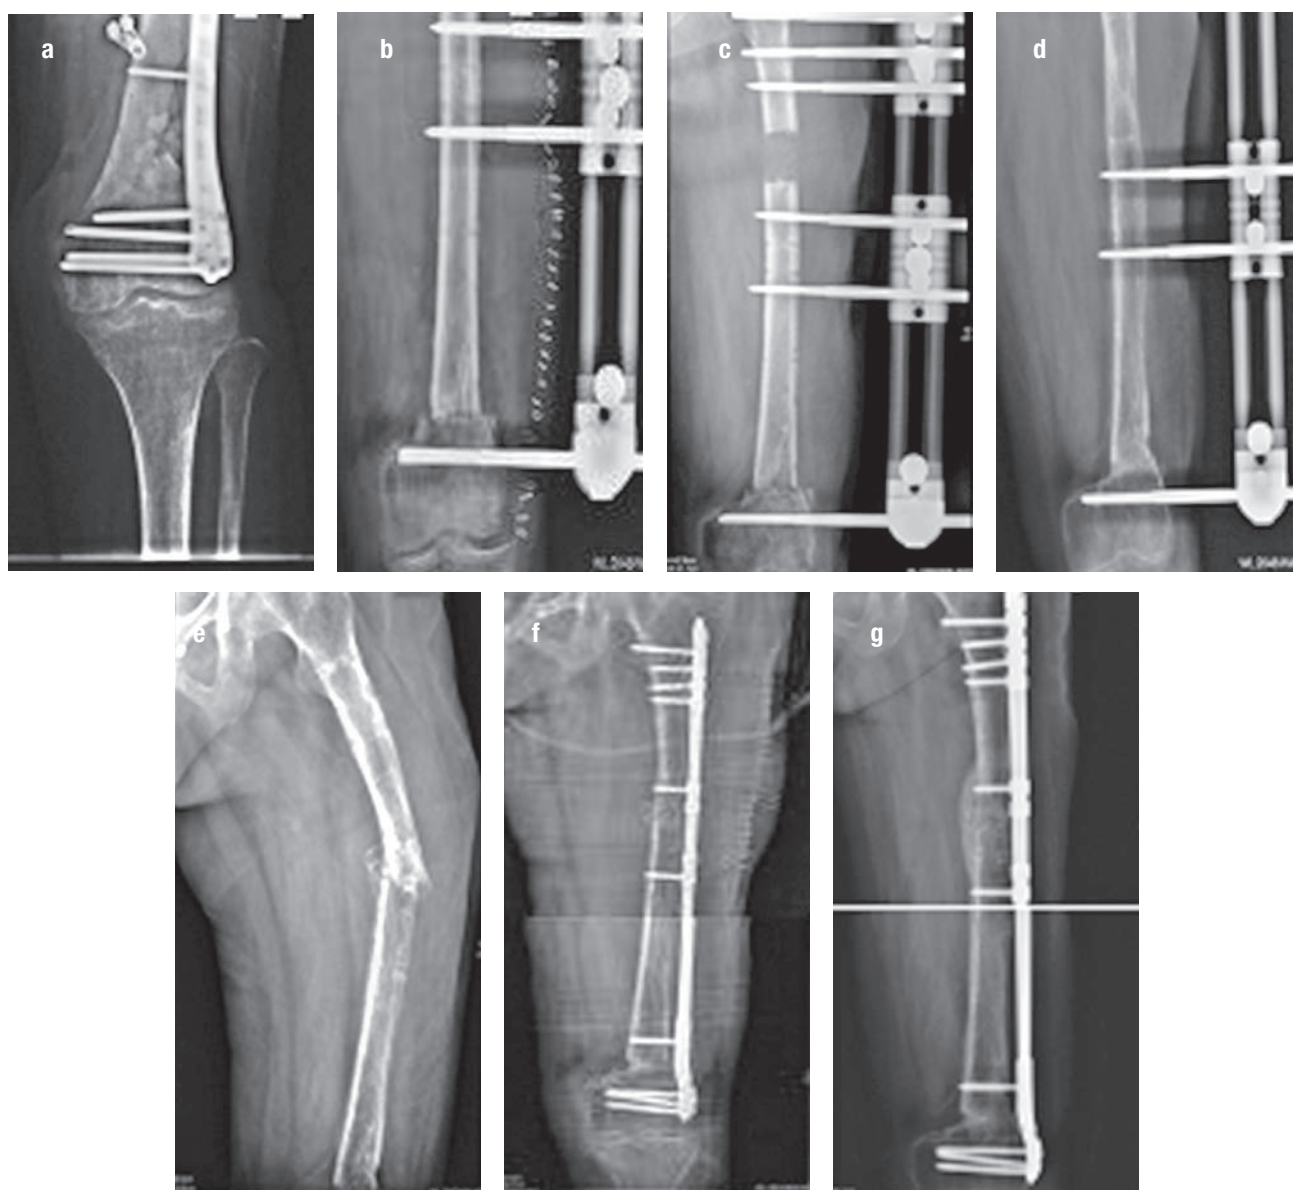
62-year-old female patient underwent bone transport after resection of infected bone segment of infected nonunion of left femur: (a) the postoperative bone transport preoperative femoral anteroposterior X-ray; (b) the infection bone segment resection postoperative femoral anteroposterior X-ray; (c) the bone transport postoperative femoral anteroposterior X-ray; (d) the Bone transport completed femoral anteroposterior X-ray; (e) the postoperative femoral anteroposterior X-ray; (f) internal fixation postoperative femoral anteroposterior X-ray; (g) the Postoperative 4 months and a half after femoral anteroposterior X-ray.
